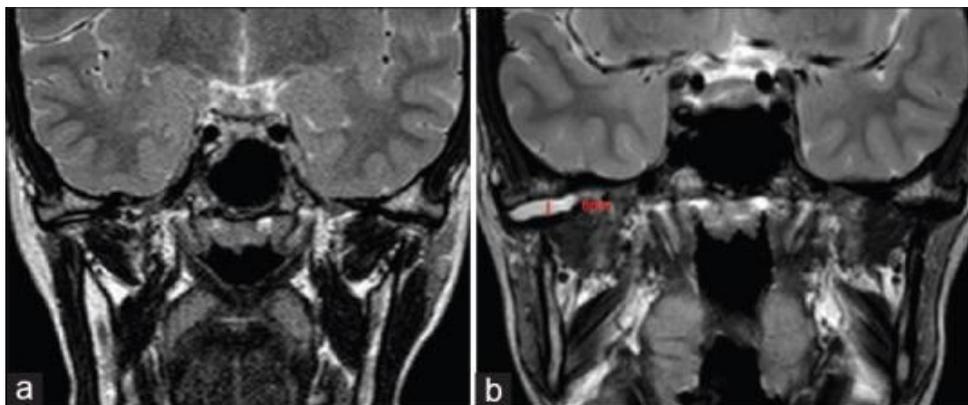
A:coronal T2 magnetic resonance imaging (close mouth) before temporomandibular joint arthrocentesis. B: coronal T2 (close mouth) after procedure upper joint space increased 6 mm.
